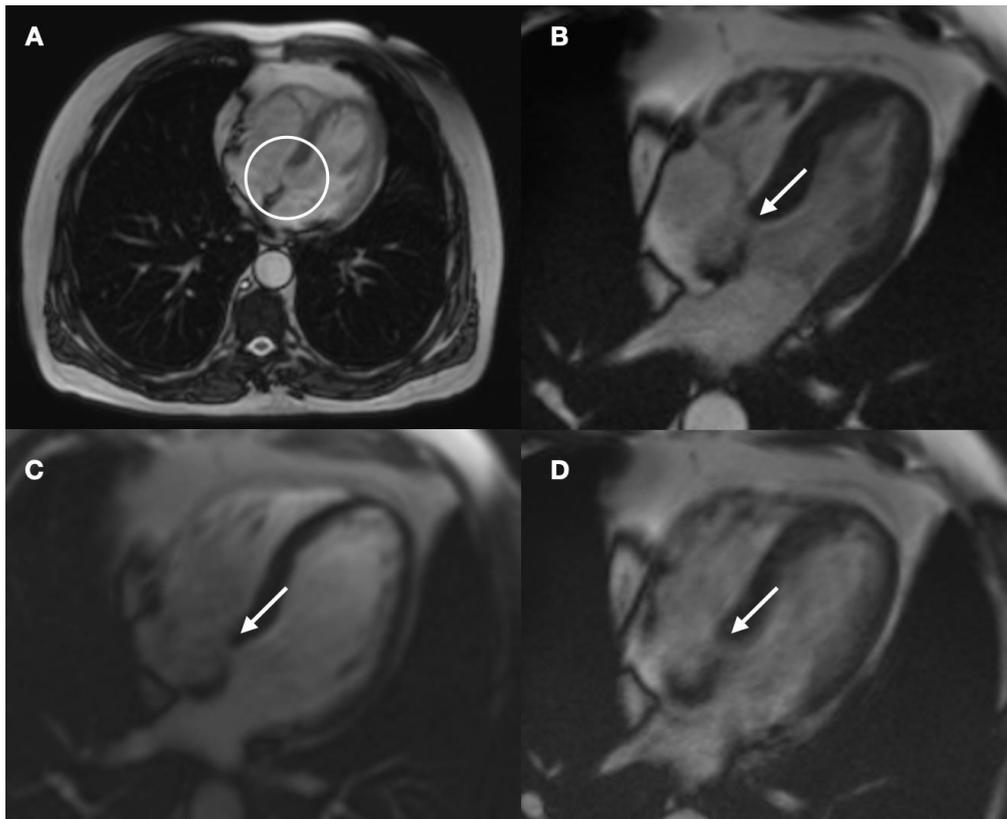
MRI showing the ventricular defect in the basal portion of the interventricular septum
